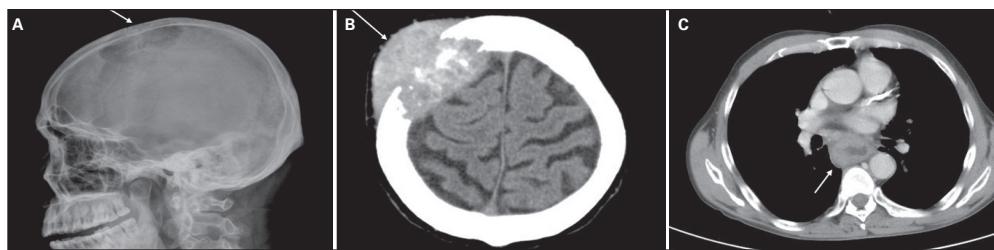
(A) Skull radiograph showing an osteolytic lesion over the right frontal bone. (B) Noncontrast computed tomography (CT) scan of the brain showing 1 skull tumour with destruction of the bone over the right superior frontal region; it measured about $5.68 \times 4.17 \times 4.8$ cm in size with expansion outward and inward to cause mild compression of the brain. (C) Contrast-enhanced CT scan of the chest showing lobulated wall thickening of the distal portion of the esophagus.
